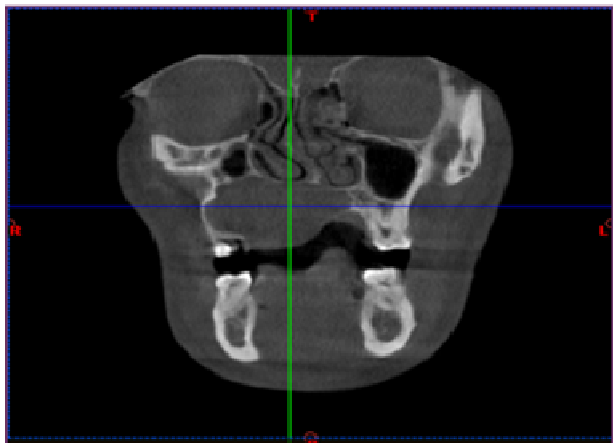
Radiograph showing extension of the tumour
